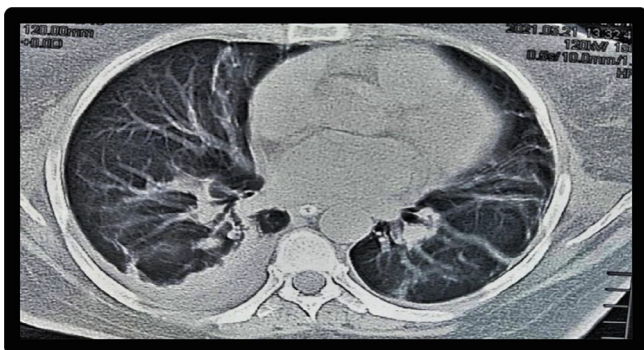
HRCT CHEST shows bilateral lung fibrosis consistent with resolved infection.
